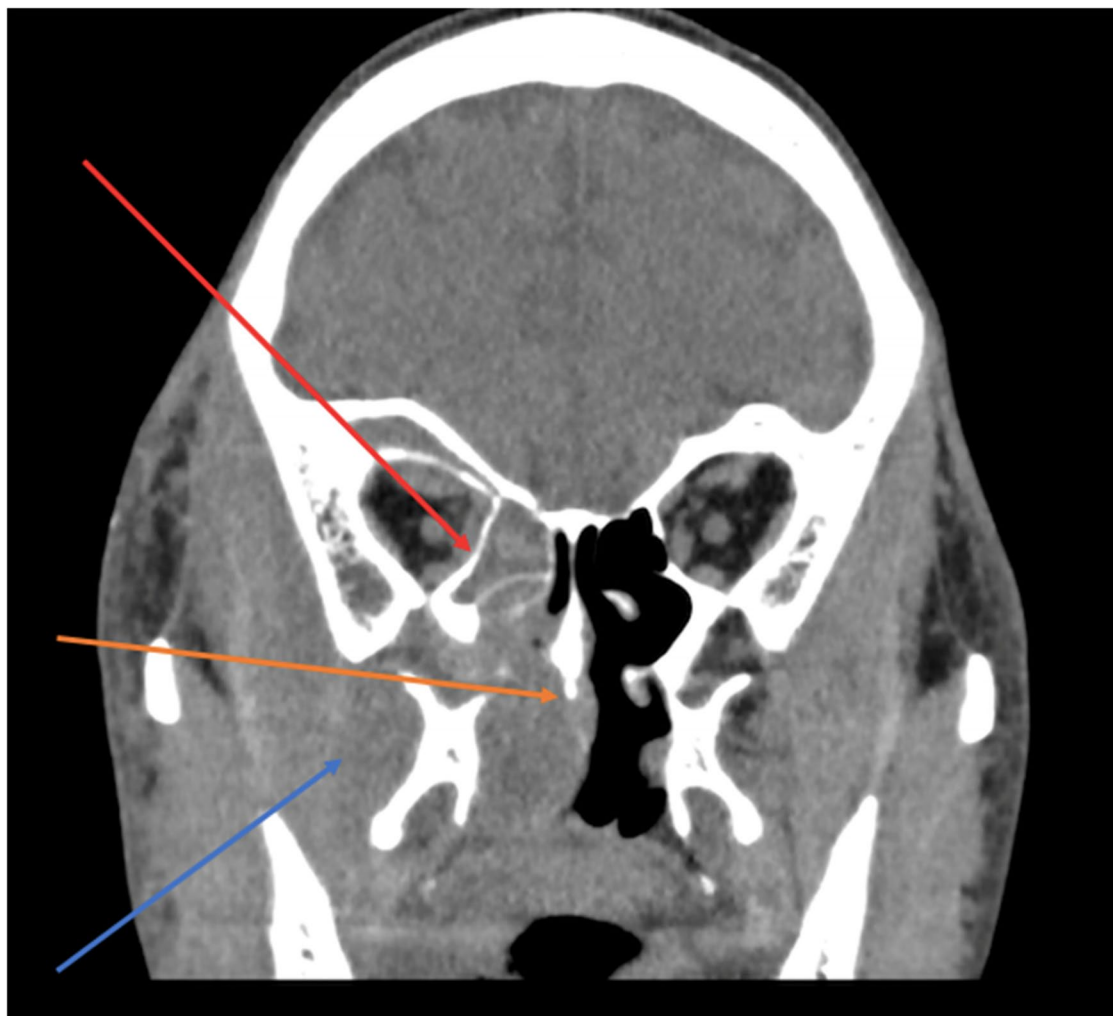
CT coronal view - right buccal mass extending into the right orbit and right sinonasal spaces
